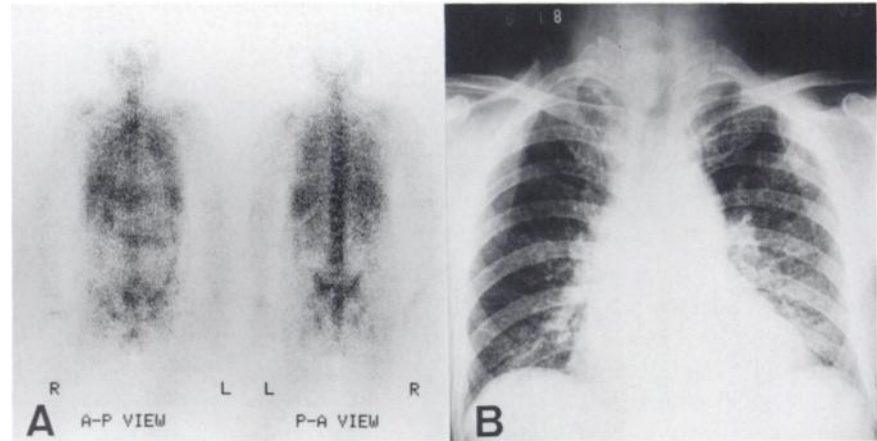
This 73-yr-old male patient had extrapulmonary TB lesions in the lumbar vertebral bodies. (A) The ^{67}Ga lung scan revealed diffused ^{67}Ga uptake in both lungs; however, the chest x-ray demonstrated localized lesions in the upper portions of both lungs (B). (C) The bone scan revealed increased MDP uptake in the lumbar spine (arrows), and (D) the ^{67}Ga scan showed congruent ^{67}Ga uptake in the same area (arrows).
